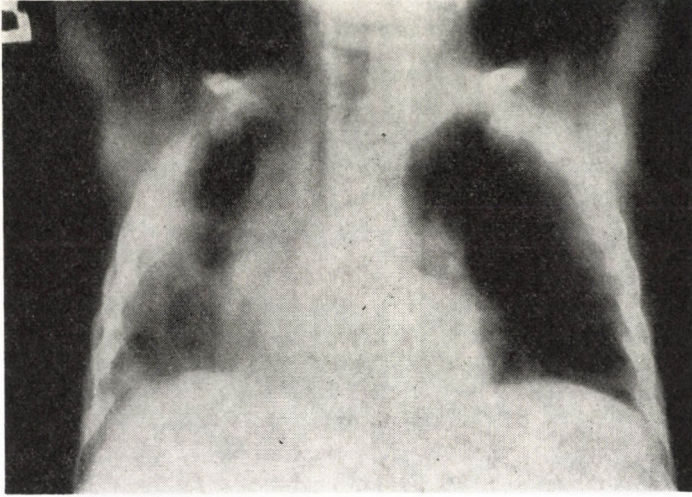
Chest X-rays 10 days after ingestion of paraquat: massive infiltration of whole right lung, moderate infiltrate on left side
